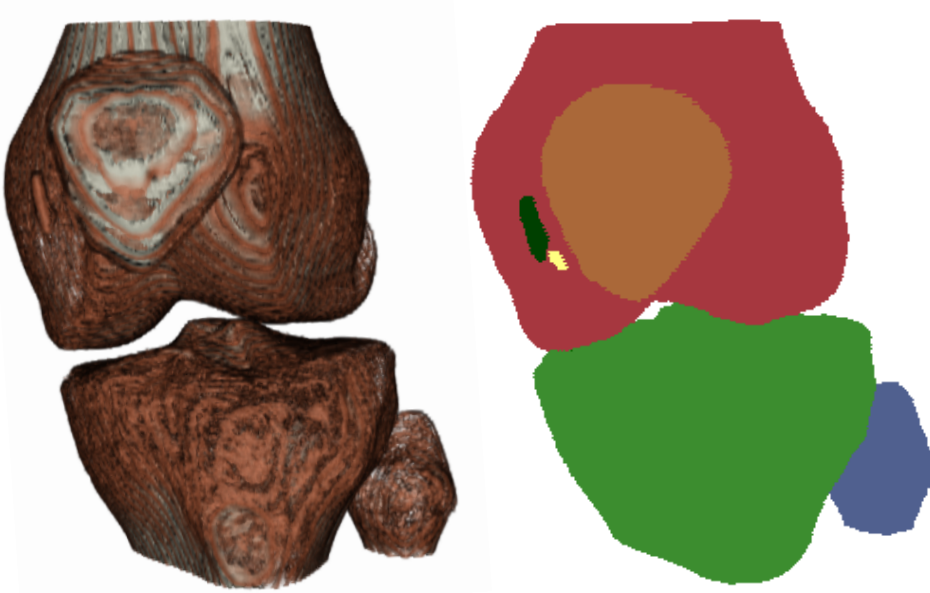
Volumetric visualization of a set of bone fragments generated from a CT stack using the presented approach (left). Since all the fragments are labelled, they can be displayed as individual fragments (right).
